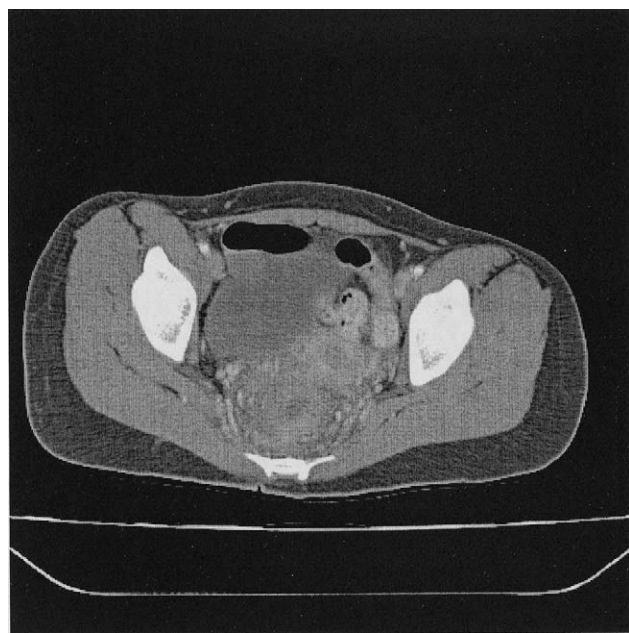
Computed tomography scan showing rectosigmoid inflammation with bowel wall thickening and enhancing lymphadenopathy.
